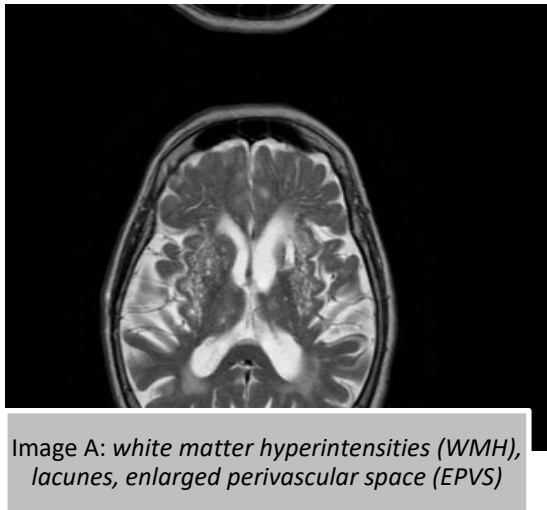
MRI brain sequences, T2 fast spin-echo(FSE) image A and T2*gradientecho (GRE)image B
